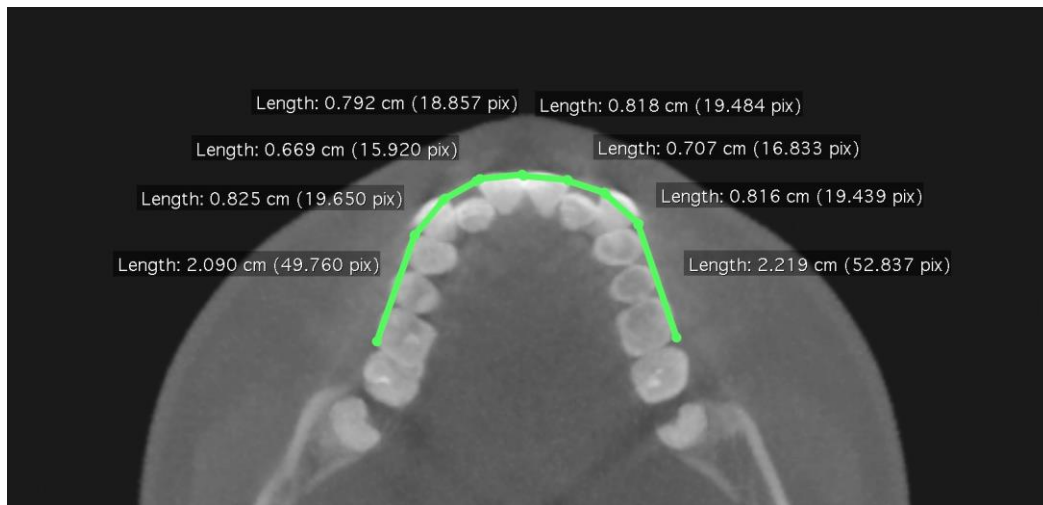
CBCT measurements on Osirix to determine the arch length.
